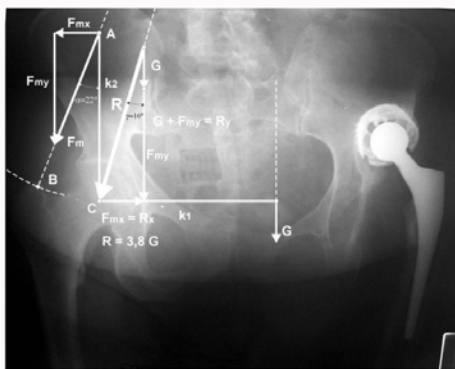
Postoperative radiograph of the pelvis. Right hip with normal biomechanics in balance, $R=3.8\text{ G}$. On the left (dislocated) hip, acetabular component of hip prosthesis is implanted in the neoacetabulum. Femoral part of the prosthesis pulled the femur (and great trochanter) distally. Stem is in valgus, long neck.
